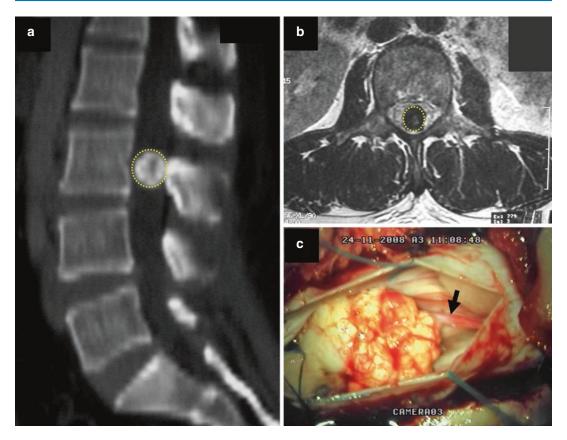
Calcified intradural tuberculoma attached to the filum terminale at L3 spinal level. Spinal CT scan on bone windows after sagittal reconstruction (a), axial spinal MRI
